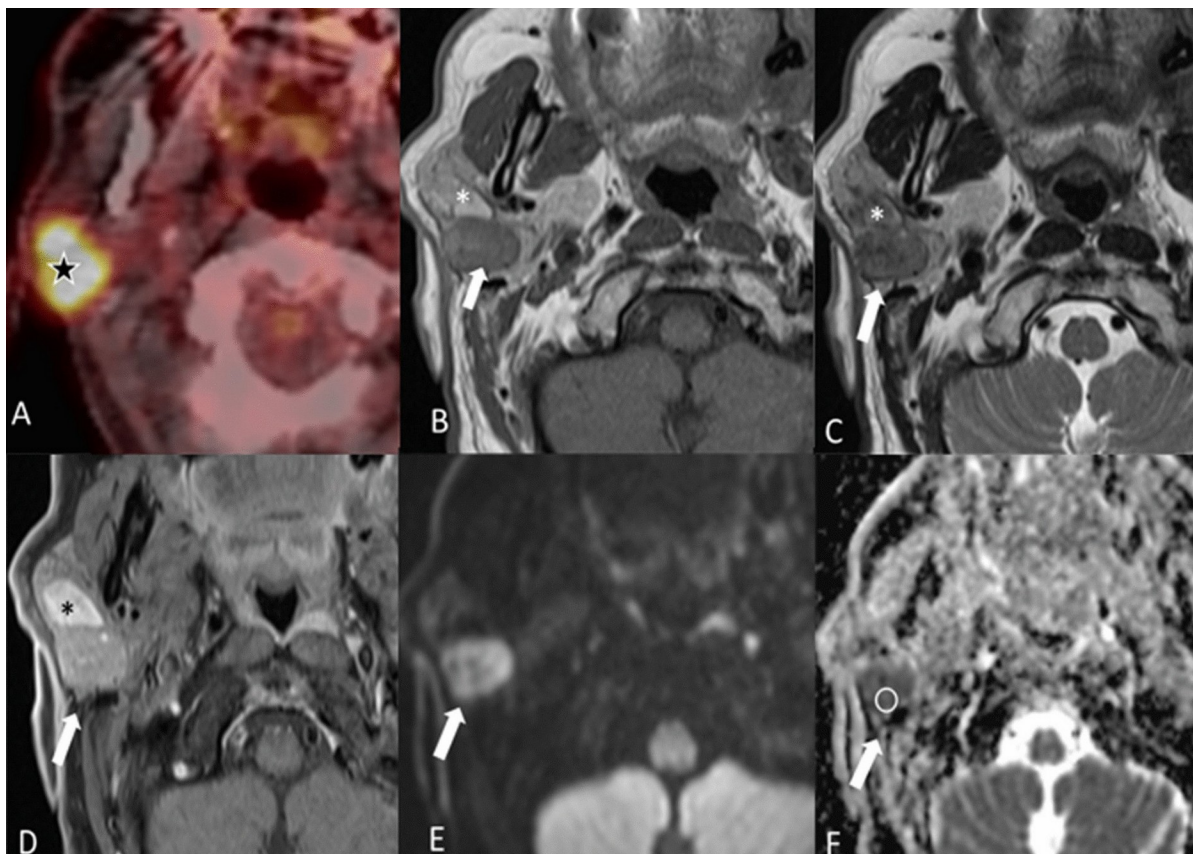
Warthin tumor with intense FDG uptake and diffusion restriction. The panel demonstrates why PET avidity and a low ADC value cannot be interpreted as synonymous with malignancy. Kim et al., *BMC Medical Imaging* 2022; open-access CC BY 4.0.
